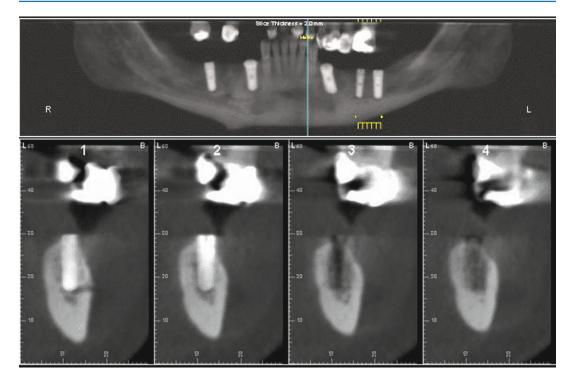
Panoramic and CT image indicating impingement of the left inferior nerve by a dental implant
